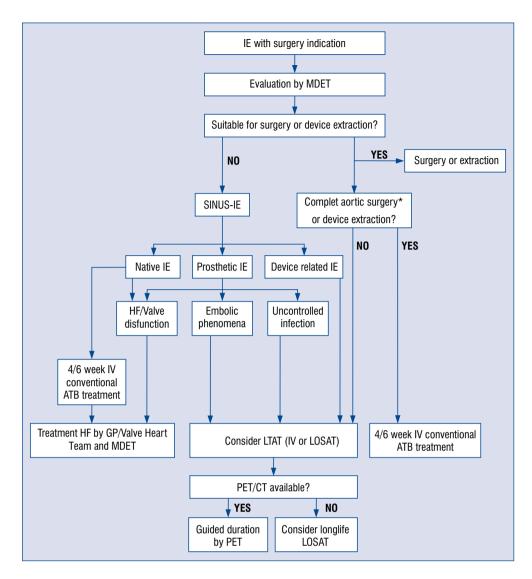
Proposed algorithm for treating surgery indicated, but did not undergo surgery for infective endocarditis (SINUS-IE) with long term antibiotic treatment (LTAT); MDET — multidisciplinary endocarditis team; IE — infective endocarditis; IV — intravenous; HF — heart failure; GP — general practitioner; LOSAT — long-term oral suppressive antibiotic treatment; PET/CT — positron emission tomography/computed tomography; ATB — antibiotherapy; *In cases of ascending aortic graft preservation.
